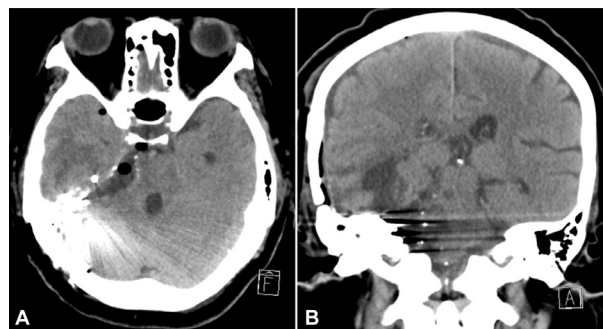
(A) Axial and (B) coronal views of computed tomography of the brain, obtained the following day after a two-stage of surgery, confirm no residual tumor.
